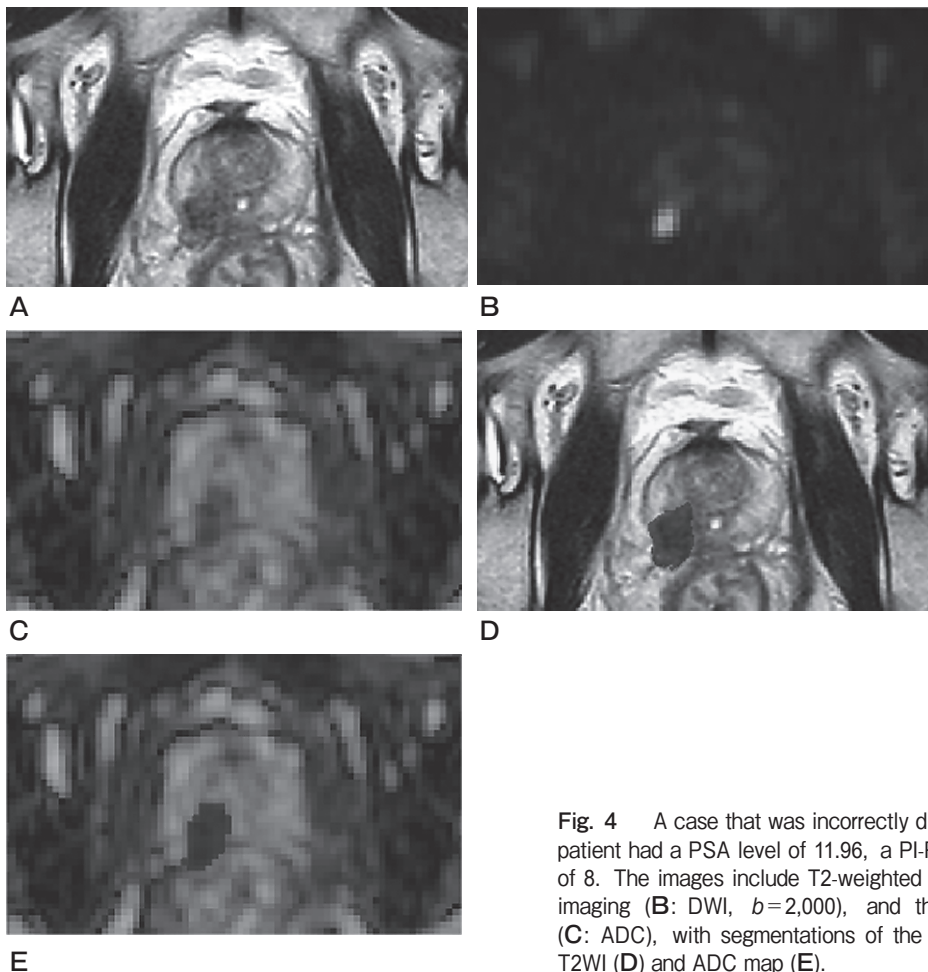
A case that was incorrectly diagnosed by the Radiomics model. The patient had a PSA level of 11.96, a PI-RADS score of 5, and a Gleason score of 8. The images include T2-weighted imaging (A: T2WI), diffusion-weighted imaging (B: DWI, $b=2,000$), and the apparent diffusion coefficient map (C: ADC), with segmentations of the lesion highlighted in dark gray on the T2WI (D) and ADC map (E).
